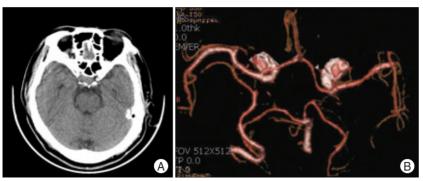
A : Non-enhanced computed tomography (CT) demonstrating a noncystic homogeneous intrasellar mass without evidence of subarachnoid hemorrhage. B : CT angiography shows no evidence of intracerebral aneurysm.
